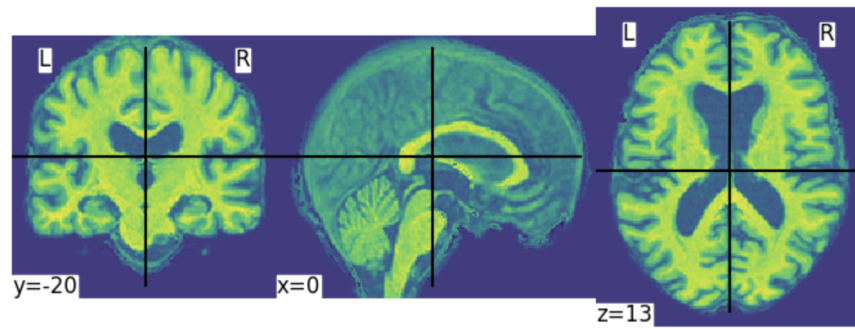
Preprocessed MRI image of MCI subject
